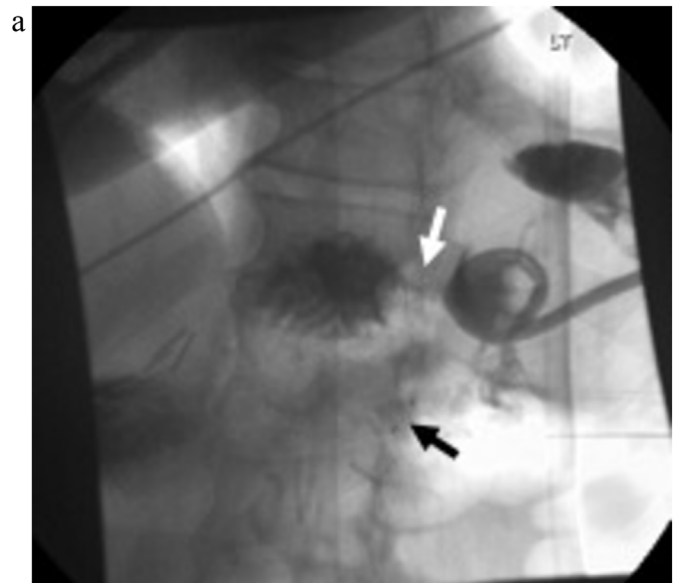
(a) Fluoroscopy and (b) coronal CT images. Contrast injected into the pigtail drain within the pancreaticocutaneous fistula demonstrates a new gastrocutaneous fistula near the fundus (white arrow), located approximately 3 cm from the distal pancreatectomy site (black arrow).
